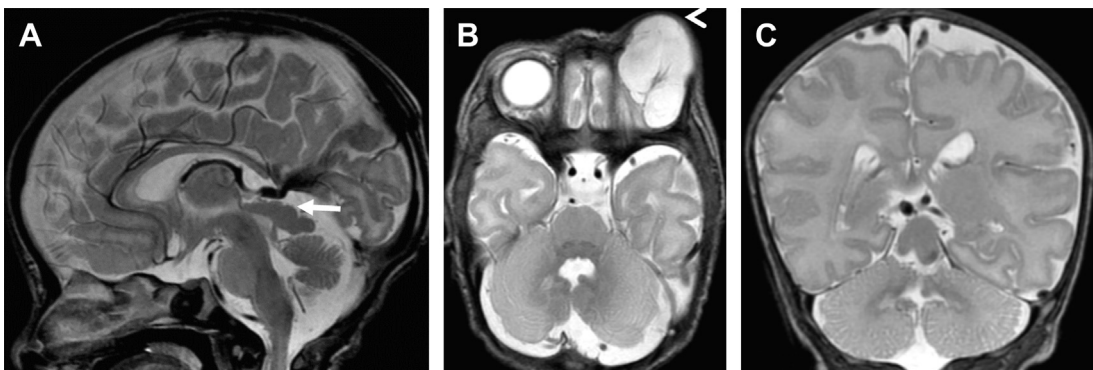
OCCS. Sagittal, axial, and coronal T2-weighted images showing (A) giant dysplastic tectum (arrow), (B) left orbital cyst (arrowhead), and (C) absent vermis.
